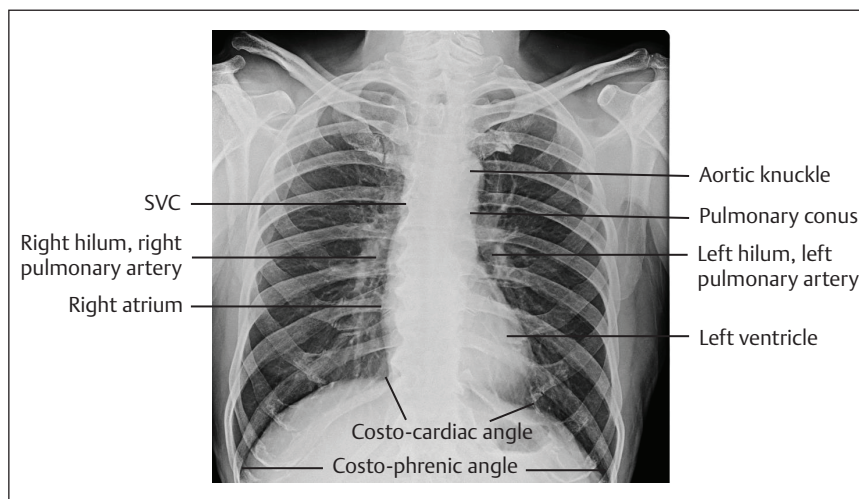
4 Cardiac shadow in chest radiograph. SVC, superior vena cava.
